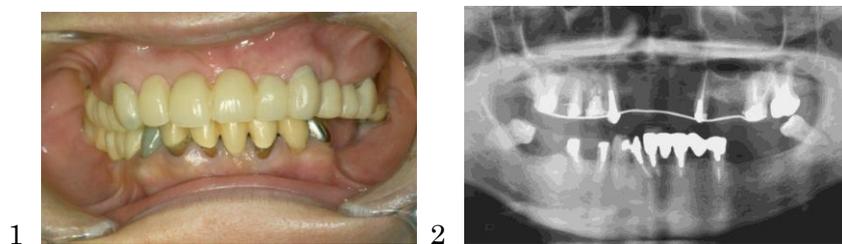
2: Panoramic radiograph at the time of first medical examination (09.18.2004)
